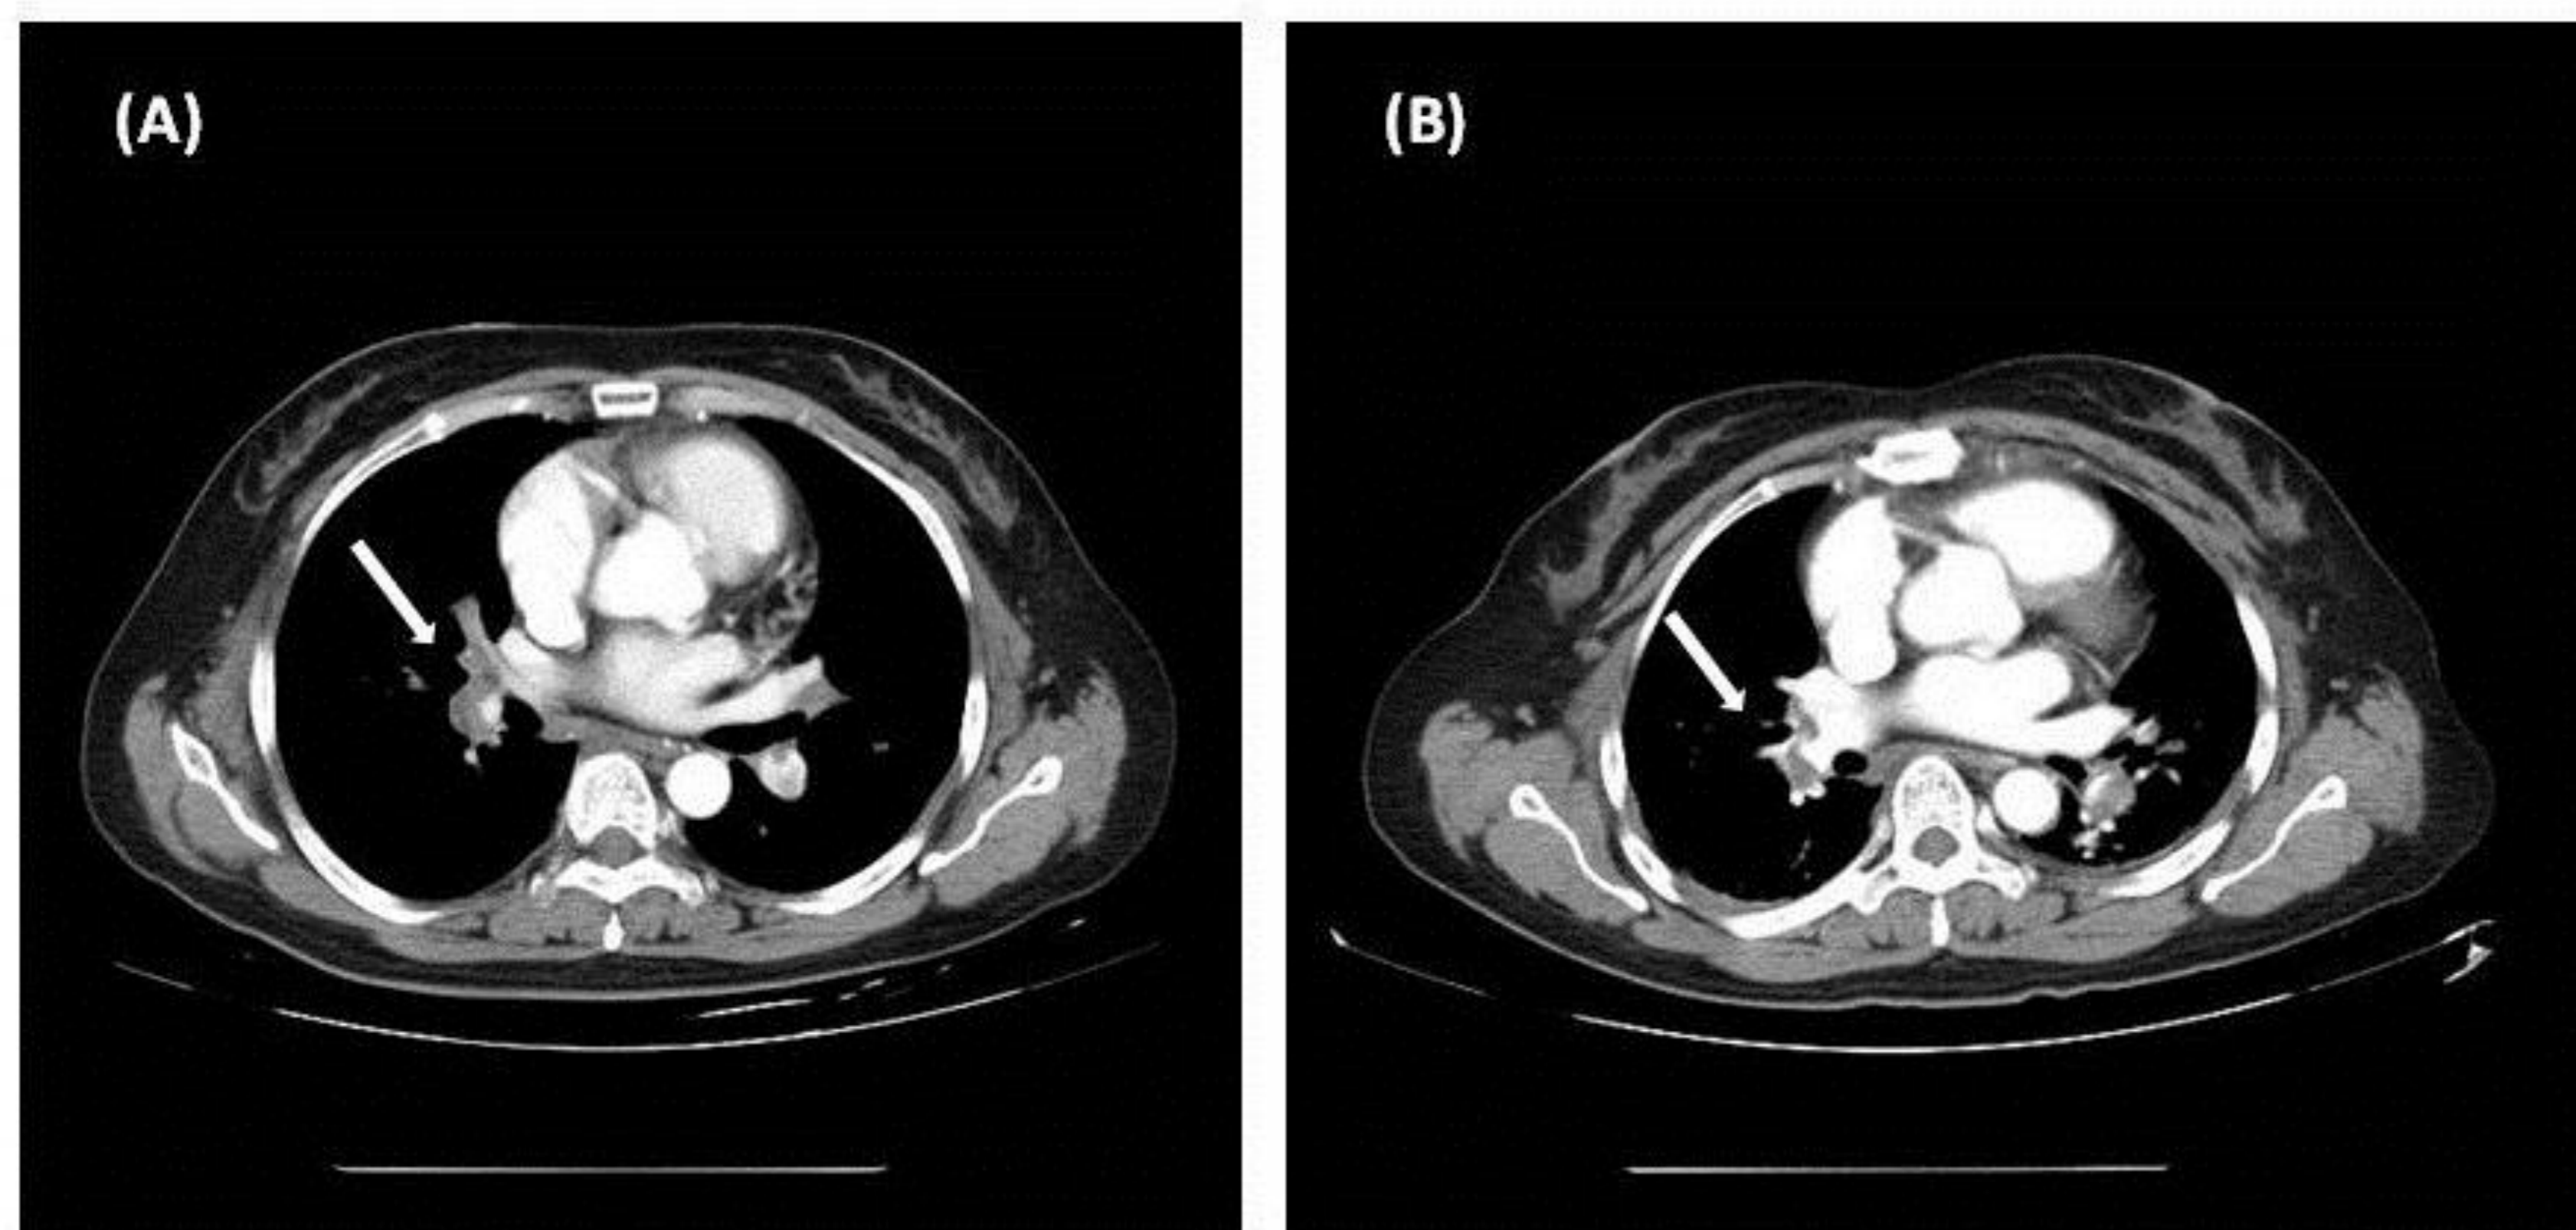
(A) Chest computed tomography indicated the presence of thrombus in the bilateral main pulmonary arteries, particularly on the right side (arrow). (B) Computed tomography showed a partial resolution of the thrombus (arrow).
